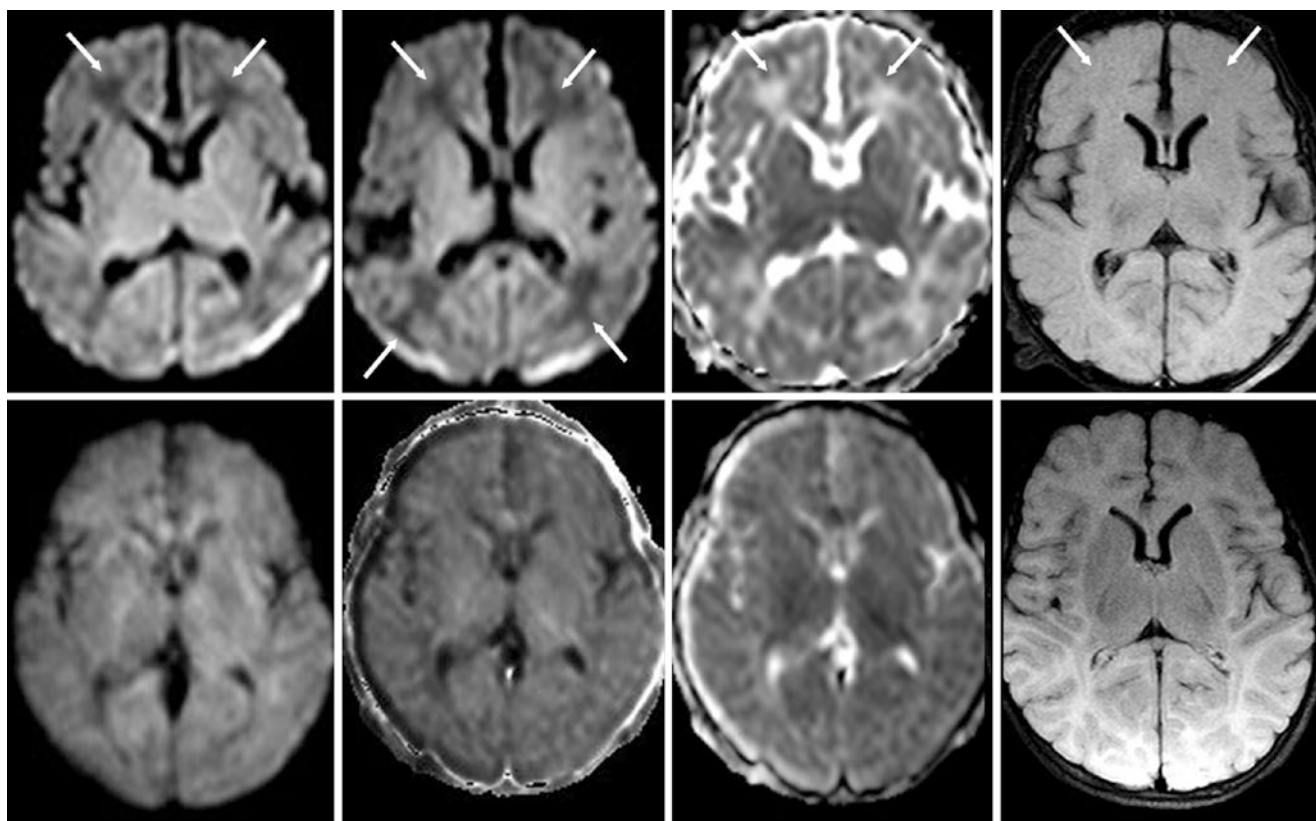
An 8-day-old term neonate with hypotonia had a normal 3T MRI and subsequent development. *Top row:* On DWI (*left* and *left middle*) there are patchy regions of hypointensity (*arrows*) that are bright on an ADC map (*right middle*) and dark on FLAIR (*right*), indicating a higher concentration of free water. *Bottom row:* another MRI at
